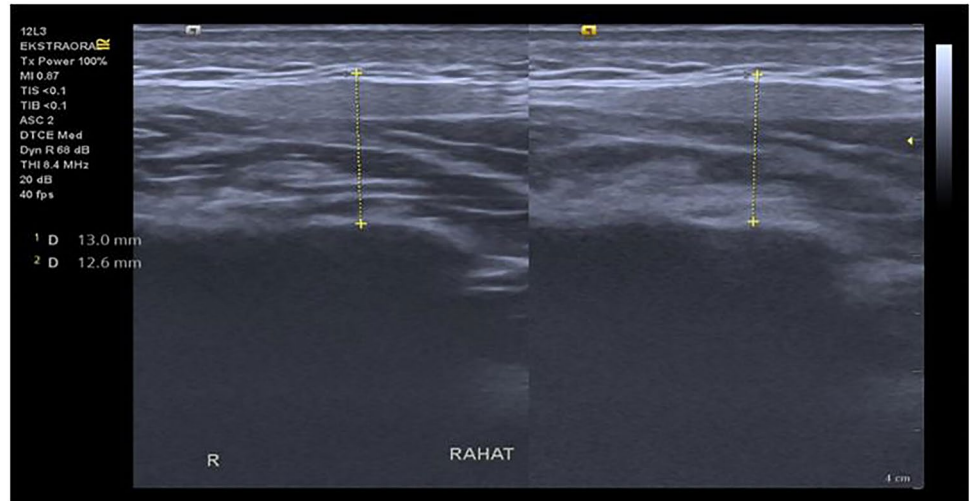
TMJ anatomy in ultrasonography and measuring joint space distance
